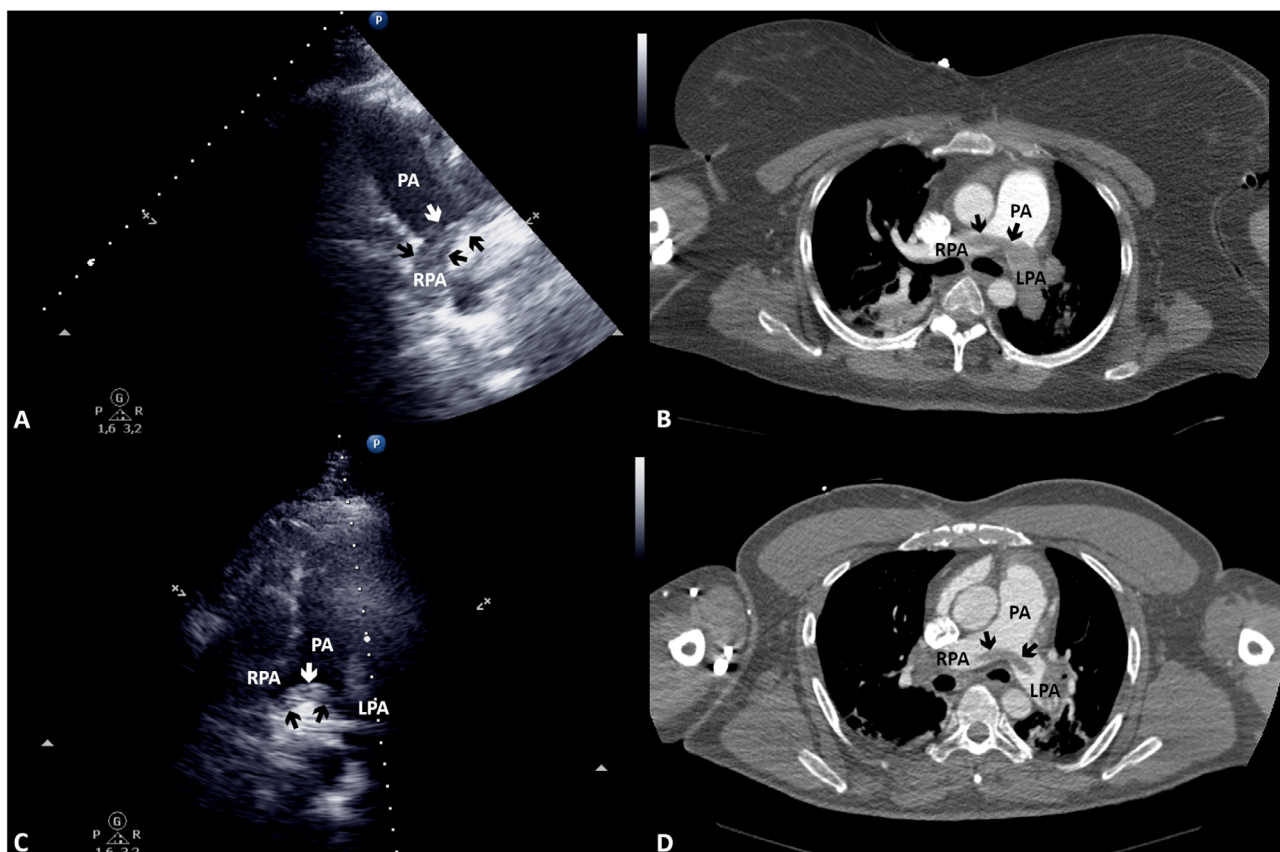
Echocardiography (A, C) and computed tomography (B, D) show pulmonary embolus (marked with arrows) in the pulmonary artery (PA) and its extension in the left (LPA) and right pulmonary artery (RPA)
